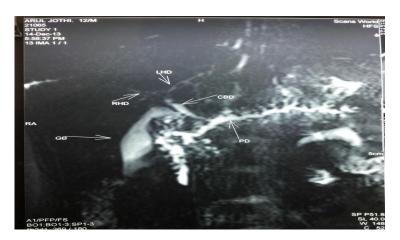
MRI showing pancreatic divisum.
